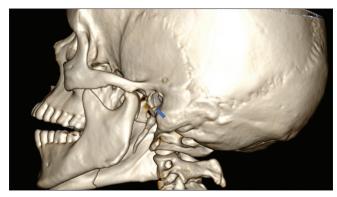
CT demonstrating EAC fracture
